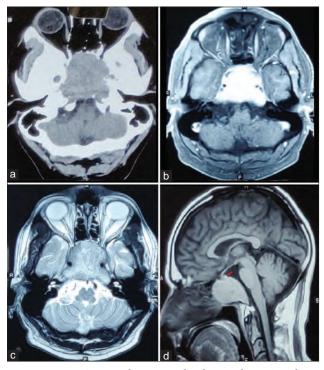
a: Computed tomography brain plain: Osteolytic homogenous sphenoidal mass, mildly hyperdense, without hemorrhage, necrosis, or calcification. b: Magnetic resonance imaging T1 axial with contrast: Solid homogenously enhancing sphenoidal mass. Smooth margins. No dural invasion. c: Magnetic resonance imaging T2 axial: Isodense solid sphenoidal mass, with a "waist" due to the indentation by ICAs. Extradural. d: Magnetic resonance imaging T1 sagittal: Isodense solid intrasphenoidal mass, with pituitary seen clearly separate (arrow)
